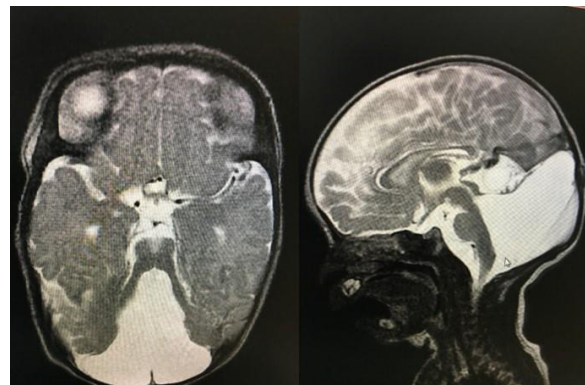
Axial and sagittal MRI: Cystic appearance enlarging the posterior fossa and associated with the 4th ventricle, hypoplastic cerebellum and corpus callosum are observed.
